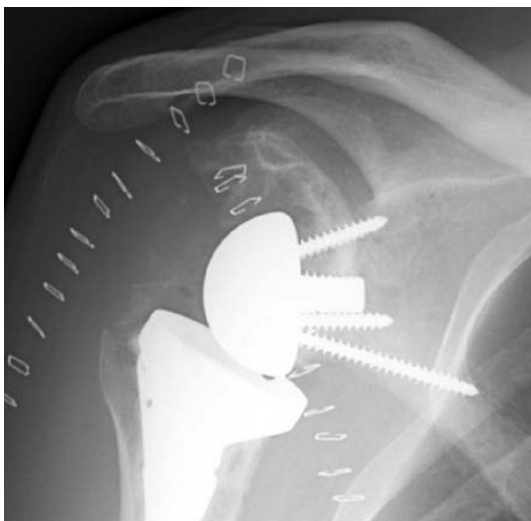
Example of a post-operative anteroposterior radiograph from a reverse total shoulder arthroplasty.¹
